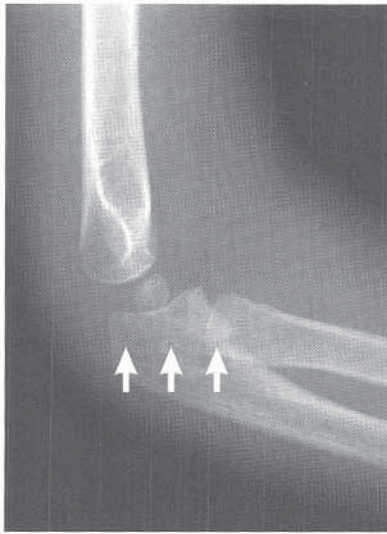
Lateral radiograph of a buckle fracture (arrowheads) through the metaphyseal bone of the olecranon.
